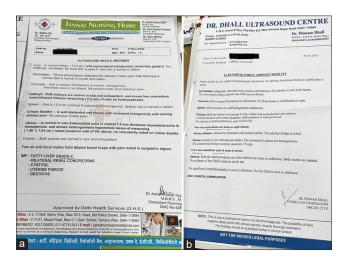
Ultrasonography reports. (a) Before treatment. (b) After treatment
